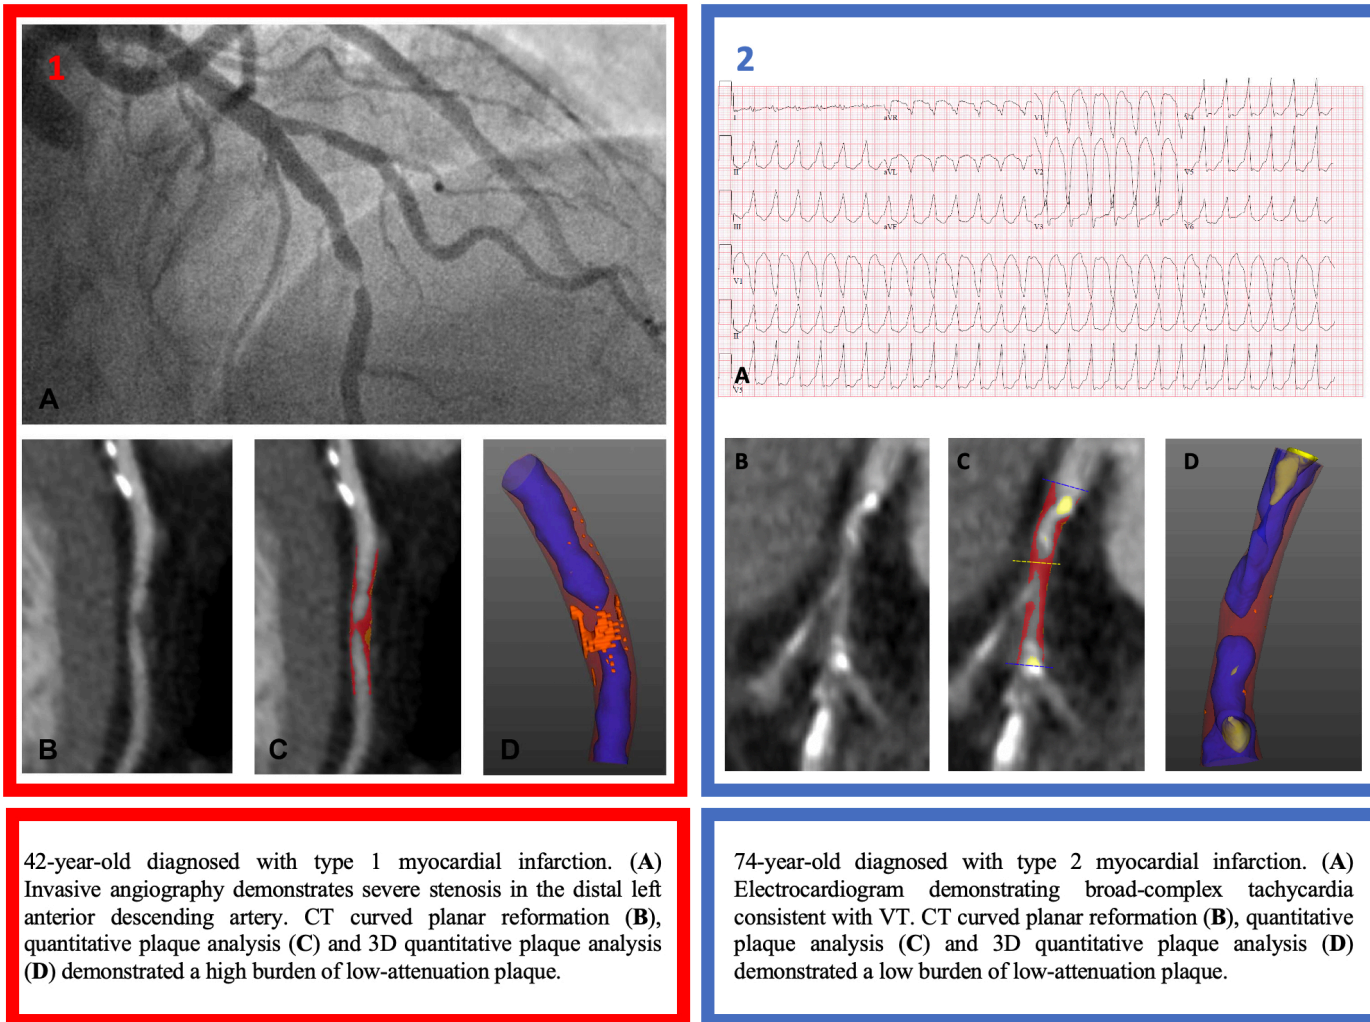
Graphical representation of CT plaque analysis demonstrating differences between type 1 and type 2 myocardial infarction.
